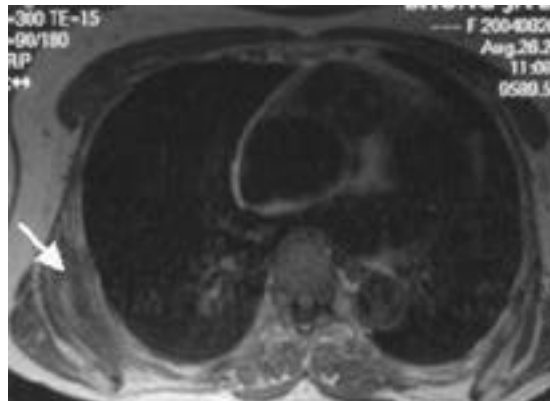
Corresponding axial T1-weighted(TR=300, TE=15). MR image shows a relatively well defined, nonhomogeneous mass(white arrow) between chest wall and scapular tip. Most of mass has a signal intensity approximately equal to that of surrounding skeletal muscle. Interspersed within mass are linear and curvilinear areas with increased signal intensity approximately the same as that of subcutaneous fat.
